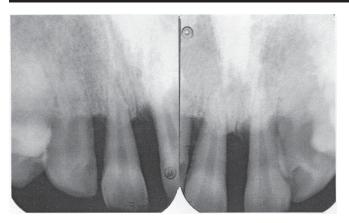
Pre-operative radiograph showing about 65 to 75% bone loss in relation to 11, 12, 21, 22
